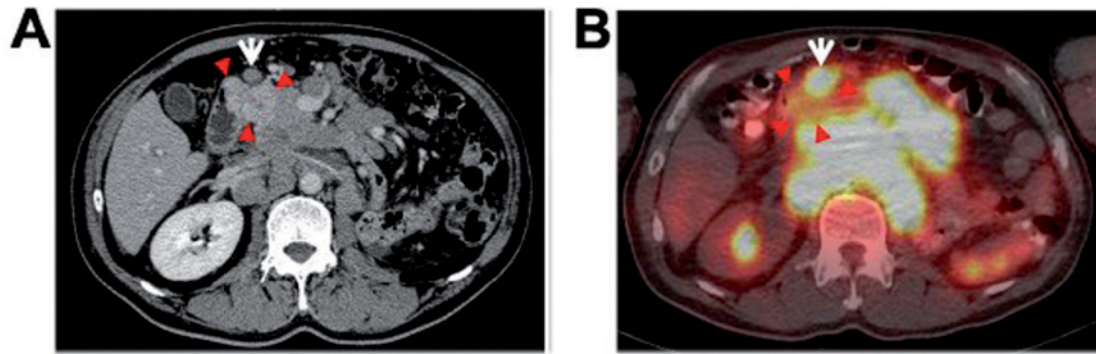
(A) CT imaging. A tumor with hypervascularity compared with the surrounding bulky mass was present in the duodenum/pancreatic head (red arrowhead). On the ventral side of the hypervascular tumor, a lymph node lesion that was enhanced similarly to the bulky mass was present (white arrow). (B) fluorine-18-fluorodeoxy-glucose (^{18}F -FDG)-positron emission tomography (PET)/computed tomography (CT). Marked uptake was noted in the bulky abdominal mass and the lymph nodes lesion described above (white arrow) [maximum standard uptake value (SUV_{max}), 30.6]. In contrast, no uptake was noted in the tumor present in the duodenum/pancreatic head (red arrowhead) (false-negative).
